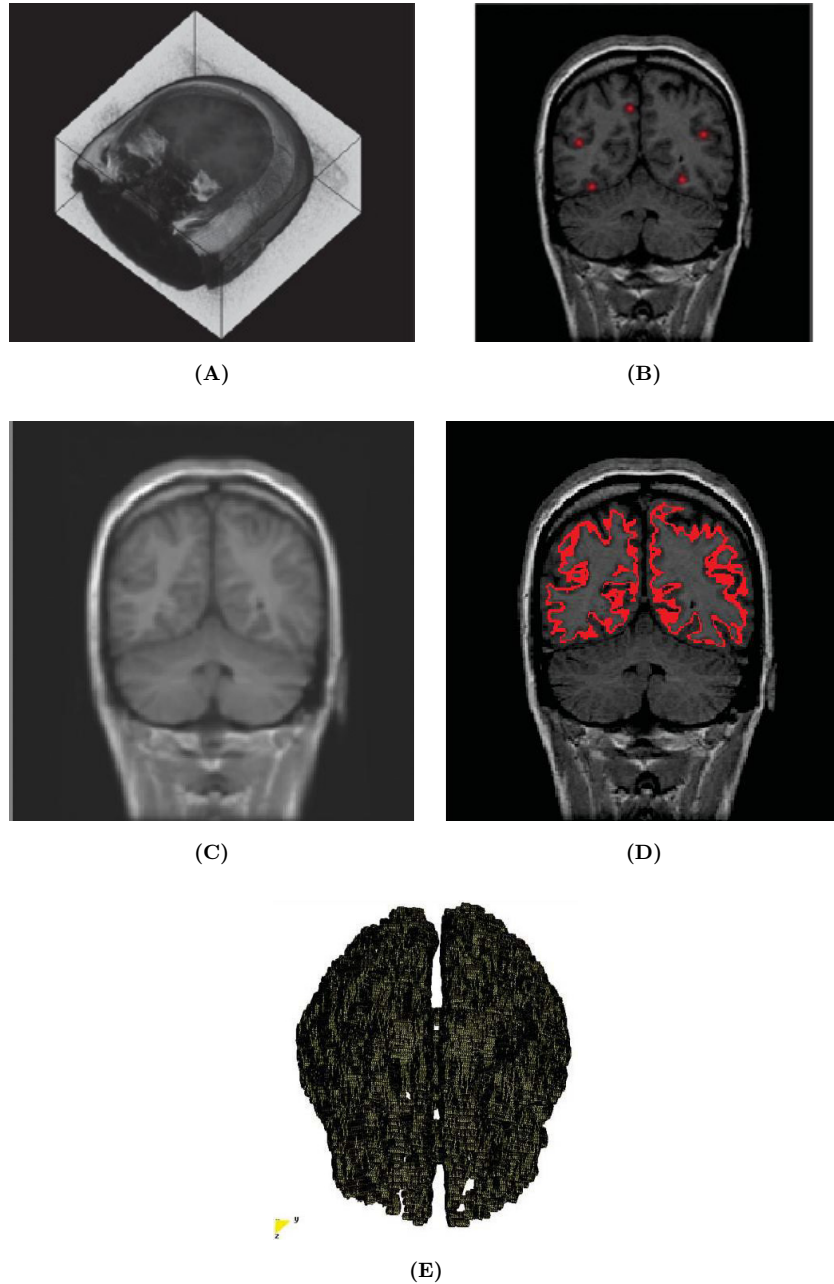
Segmentation of gray matter using region growing algorithm. (A) Original volume from brain MR images. (B) Coronal slice view with selection of five initial seeds. (C) Denoising of image using anisotropic filter. (D) Coronal slice view B with segmented gray material through growing region. (E) Volumetric view of the segmented white material in D.
